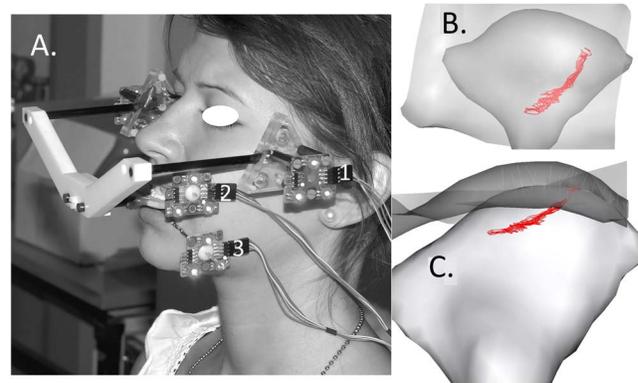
(A) Custom occlusal registration appliance with head reference system and contrast spheres for magnetic resonance imaging and (1) light-emitting diodes (LED) for jaw tracking. LED also attached to (2) maxillary and (3) mandibular labial tooth surfaces via custom brackets and glass ionomer cement. Left condyle and temporal fossa and eminence (disc not shown) in superior coronal (B) and frontal (C) views showing path of stress-field centroid (red) during symmetrical jaw closing. Modified¹⁷ with permission.
